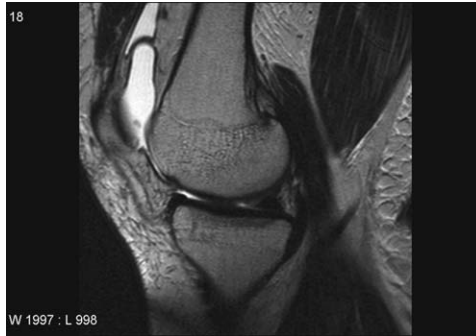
Medial patella plica. T2-weighted sagittal image shows a low signal band in the suprapatella bursa consistent with a medial plica.
